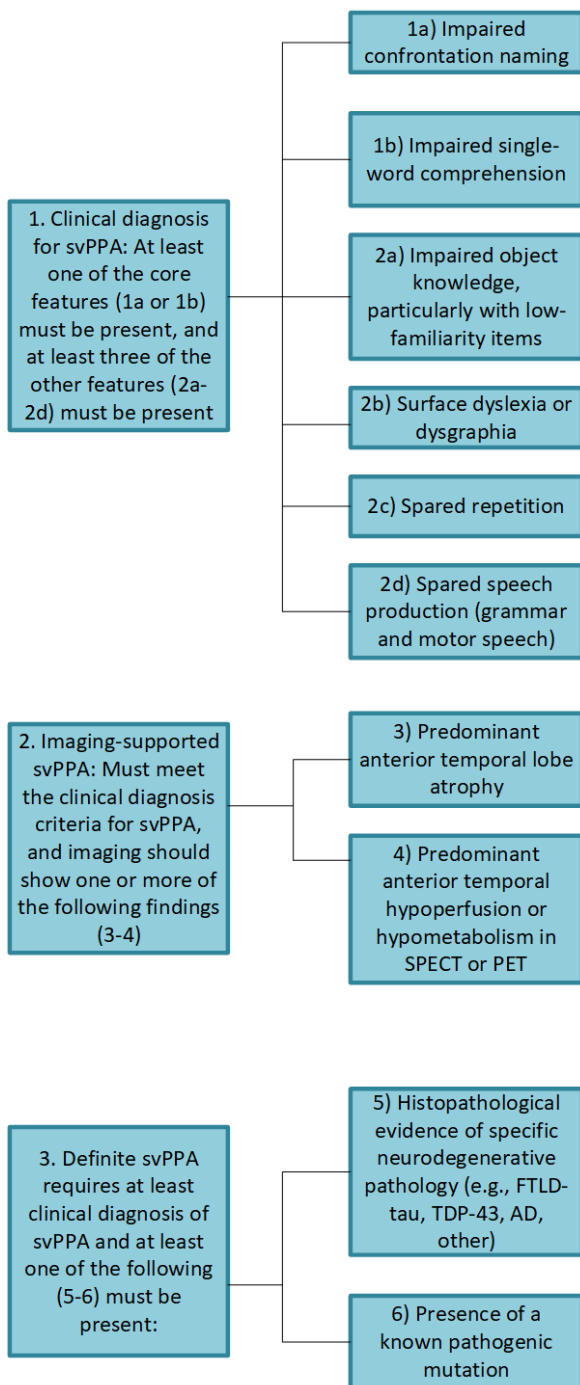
Diagnostic criteria for svPPA according to Gorno-Tempini et al. 2011. SvPPA = semantic variant of primary progressive aphasia, SPECT = single photon emission computed tomography, PET = positron emission tomography, FTLT = frontotemporal lobar degeneration, TDP-43 = TAR-DNA binding protein of 43 kDa, AD = Alzheimer’s disease.
